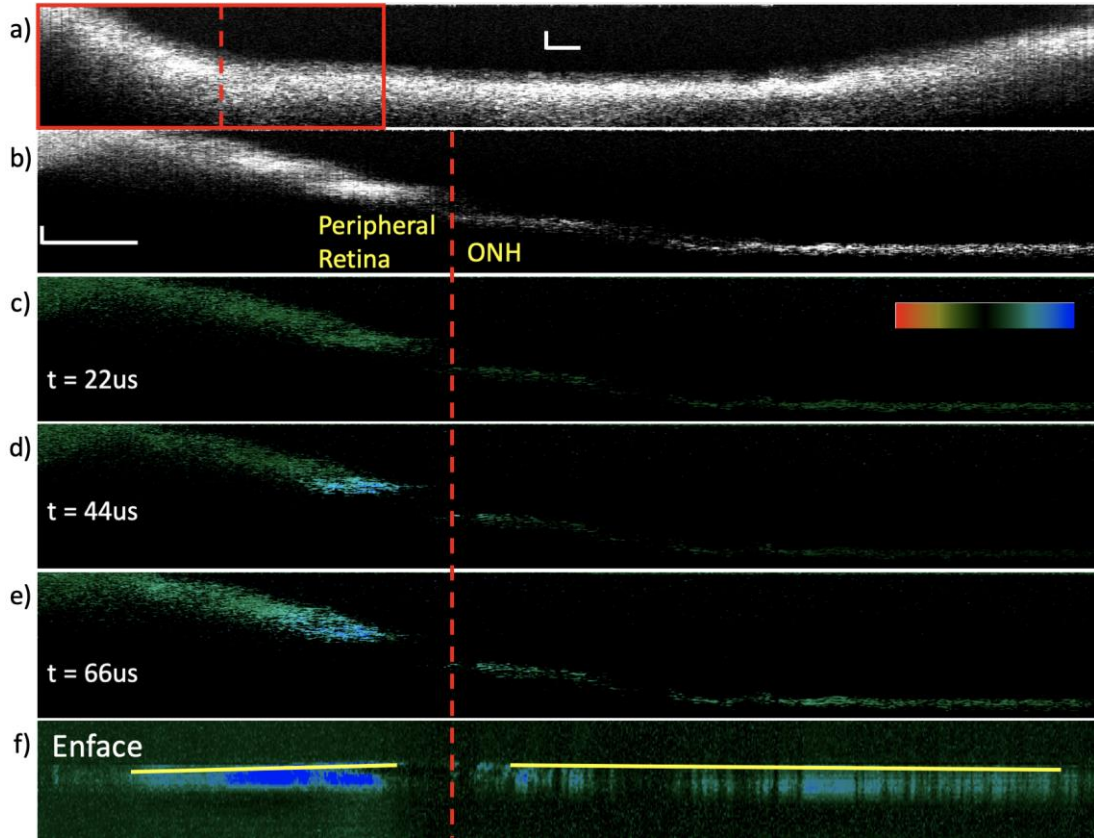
Confocal shear wave ARF-OCE results for the optic nerve head (ONH) and adjacent peripheral retina. a) OCT image of optic nerve head region. Red box is magnified in figures b-f. b) OCT image where the shear wave was applied axially at the dotted red line, to the right is the ONH region and left is the peripheral retina. Doppler OCT figures c) 22 us, d) 44 us, and e) 66 us after shear wave is induced. F) En face projection of shear wave propagation over time. Scale bar = 200 um.
